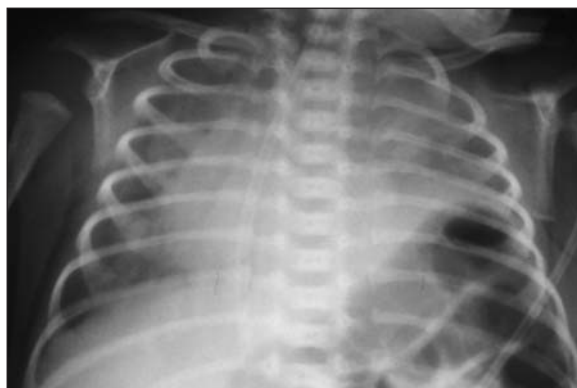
Chest X-ray demonstrating elevation of left hemidiaphragm with mediastinal shift to the right.
